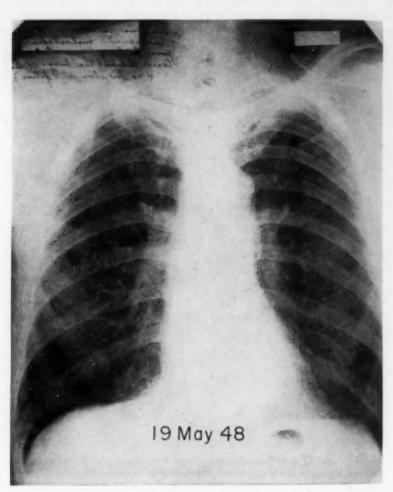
Case 5. Roentgenogram of chest taken May 19, 1948. It reveals evidence of old apical tuberculosis on the right.
